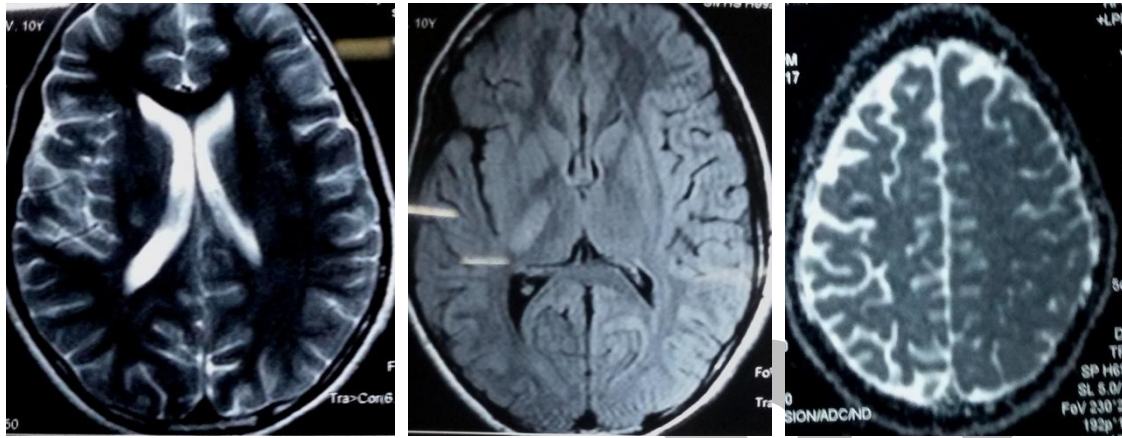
MRI brain showing atrophy of right hemisphere with ex-vacuo dilatation of ipsilateral lateral ventricle.
